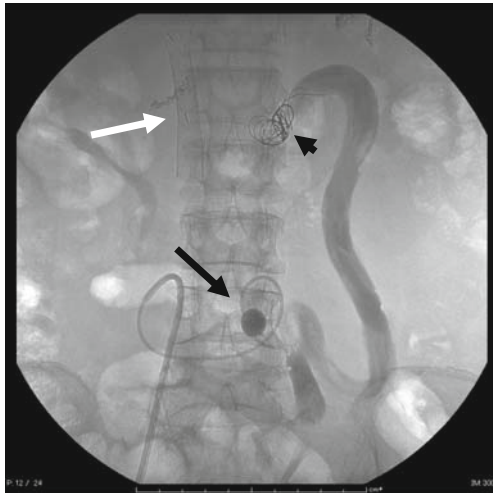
Radiograph shows the opacified sclerosant in the dilated IMV shunt between the inflated 6F balloon catheter (*black arrow*) at the efferent portion of the shunt and the microcoils (*arrowhead*) at the afferent orifice of the tortuous IMV to prevent sclerosant migration. The covered stent is clearly visualized (*white arrow*) in the portal vein and the SMV to cover the orifice of the splenic vein
